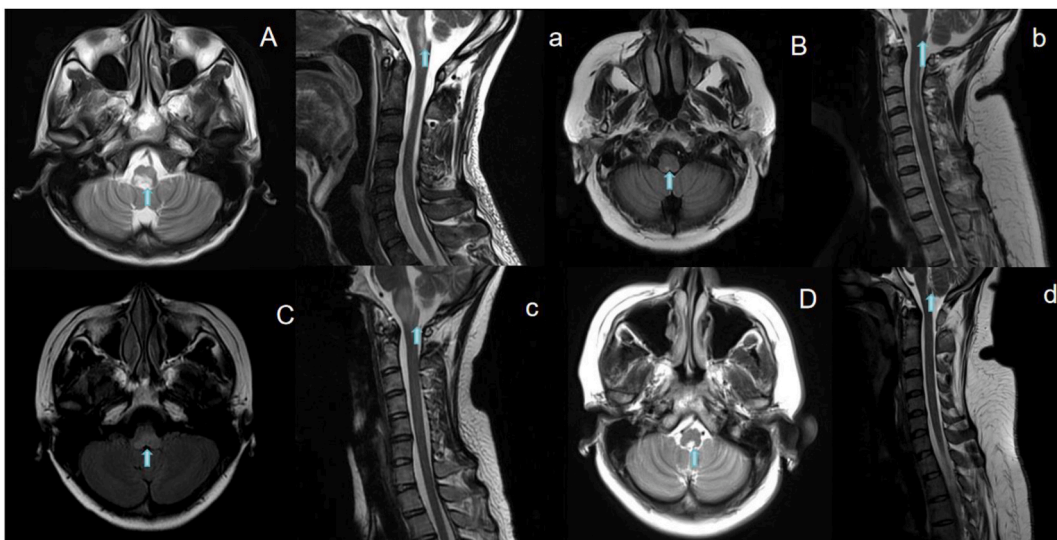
The T2-weighted fluid-attenuated inversion recovery and Sagittal T2-weighted scan showing lesions in the area postrema and multifocal lesions in medulla and cervical spinal cord in NMOSD patients.
